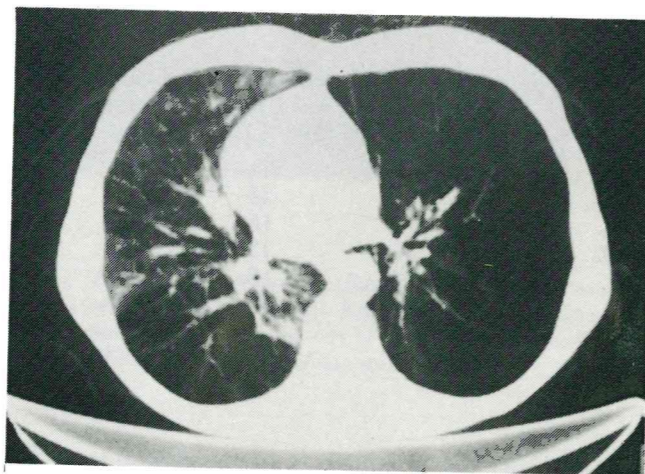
CT scan of lower zones (same patient as Fig. 3a).
